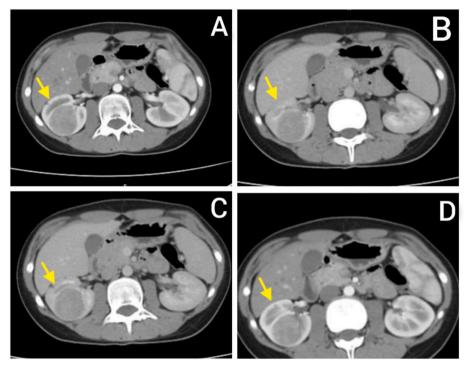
Right renal mass appearance on abdomen CT scan.
